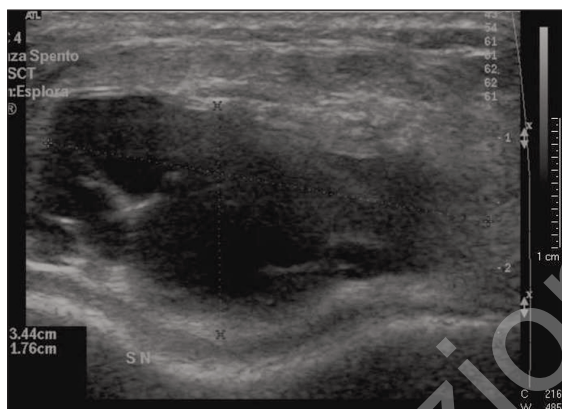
Ultrasound demonstrated a cyst, 34x17 mm in diameter, with many lacunae separated by numerous septa. A 18 GA spinal needle was inserted into the cyst and all the septa were pierced to drain all the lacunae.
